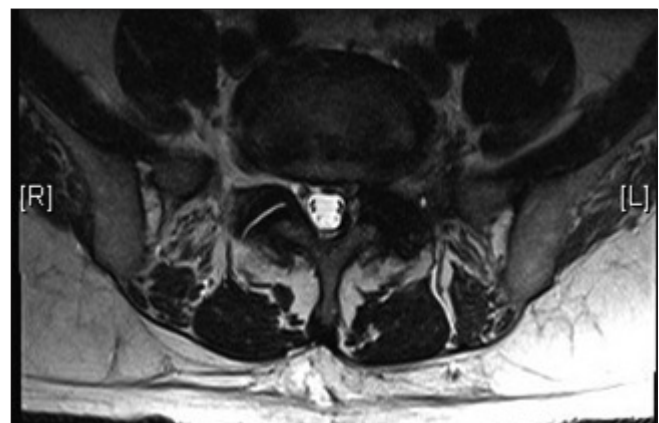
Postoperation follow-up axial T2-weighted MRI revealed no residual hematoma
